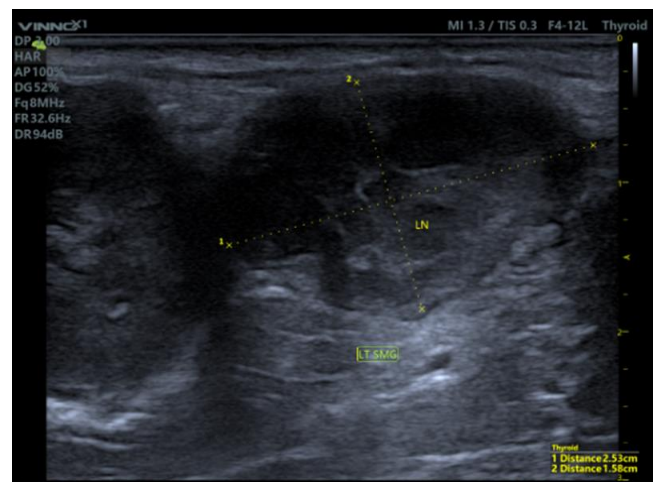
A sonogram of the left submandibular gland using a linear probe shows the dominant enlarged hypoechoic ovoid nodule with central anechoic areas, measuring about 2.53x1.58 cm in AP diameter.
